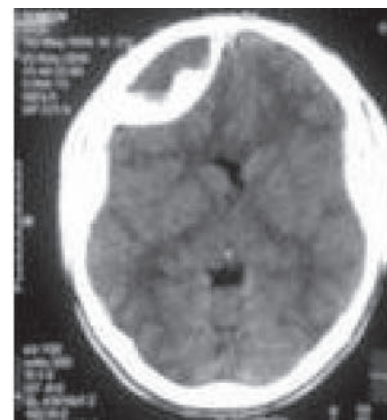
CT showing multiple bilateral epidural hematomas
